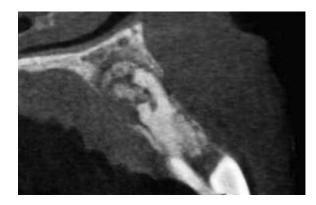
The sagittal CBCT view shows partial resorption of the root in the apical third with the residual labial third of the root in tooth #10. Note the through-and-through bony lesion and the radiopacity in the center of the periradicular radiolucency that was suggestive of a bone graft placed in the previous surgery.
